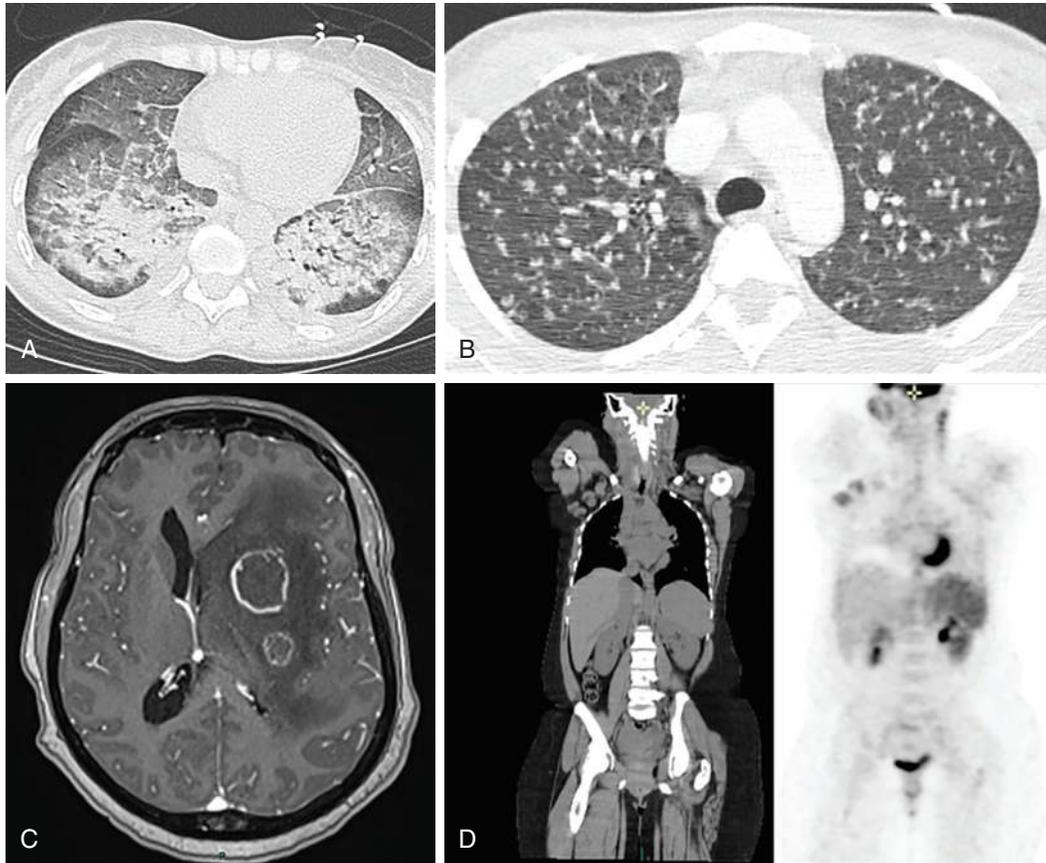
AIDS-related opportunistic infections in the ICU: typical imaging features. A, *Pneumocystis jirovecii* pneumonia (chest CT scan showing diffuse ground-glass opacities with focal alveolar consolidations, thickened septal lines, relative sparing of the subpleural regions, and absence of pleural effusion). B, Lung involvement secondary to miliary tuberculosis (chest CT scan showing bilateral disseminated nodules without typical excavation in a patient with CD4 cell count $<100/\mu\text{L}$). C, Cerebral toxoplasmosis (T1-weighted cerebral magnetic resonance imaging showing gadolinium-enhanced lesions of the hemispheric gray matter with peripheral edema and mass effect). D, Multicentric Castelman disease (positron emission tomography showing enlarged liver, spleen, and axillary/cervical lymph nodes with hypermetabolic patterns). (From Barbier F, Mer M, Szychowiak P, et al. Management of HIV-infected patients in the intensive care unit. *Intensive Care Med.* 2020;46[2]:329–342, Fig. 2.)
